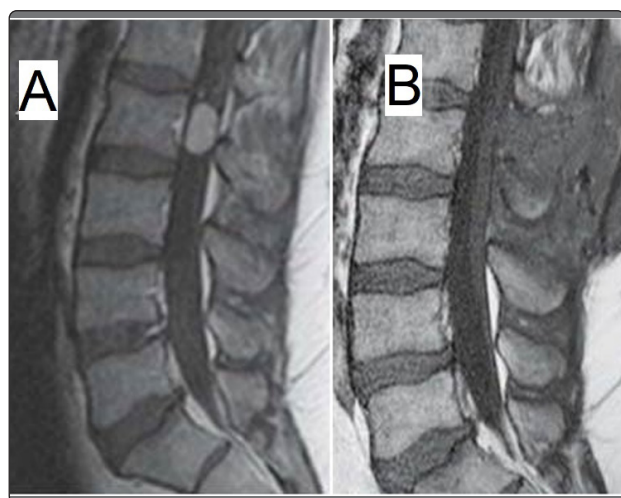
Patient's images showing (A) preoperative sagittal T1 MRI with gadolinium contrast showing intradural schwannoma at L2 level, (B) postoperative sagittal T1 MRI of the same patient showing GTR of the lesion and decompression of the cauda equina rootlets.
